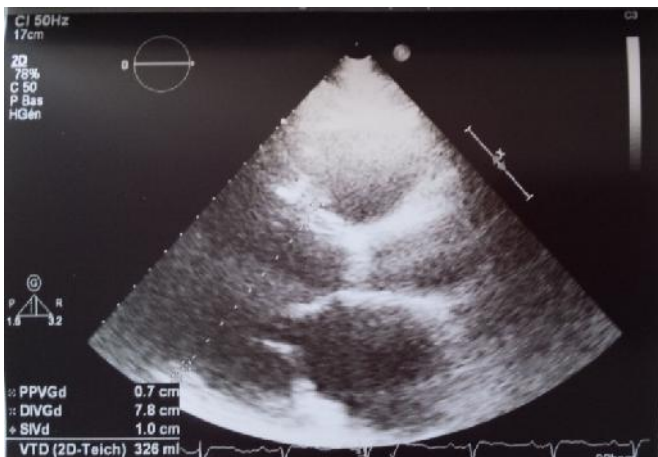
Echocardiography showing a dilated LV (parasternal)
